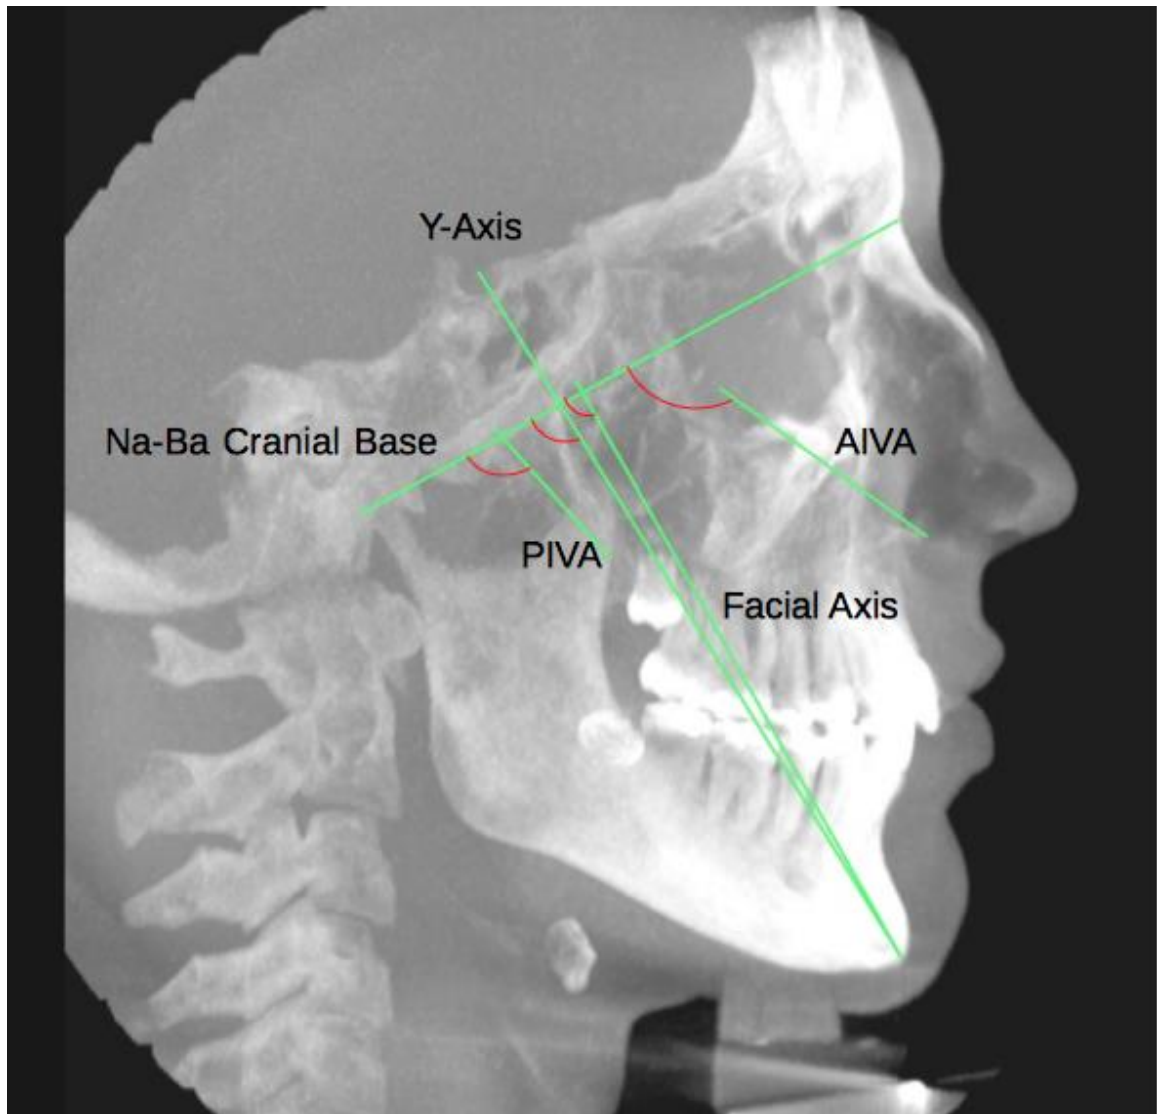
A CBCT image with reference planes labeled including the PIVA, YA (Down's analysis), FA (Ricketts analysis) and AIVA. The Ricketts Na-Ba Cranial Base was the reference plane for measurements. The red arcs indicate measured angles.
